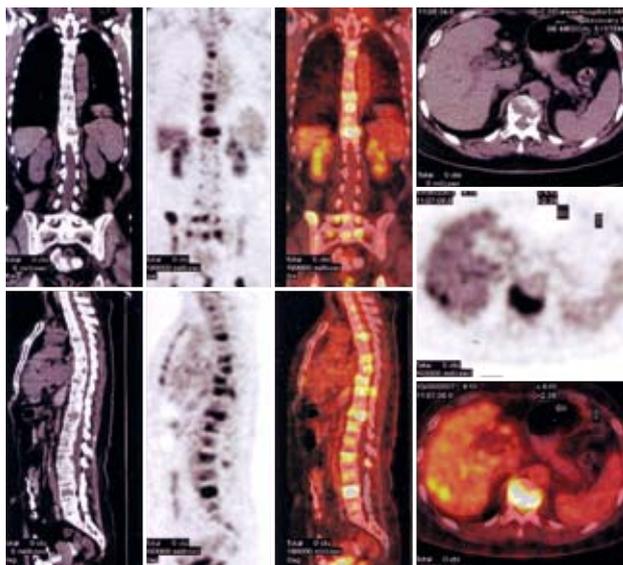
Multiple osteolytic bone lesions and nodular liver lesions (PET-CT).
